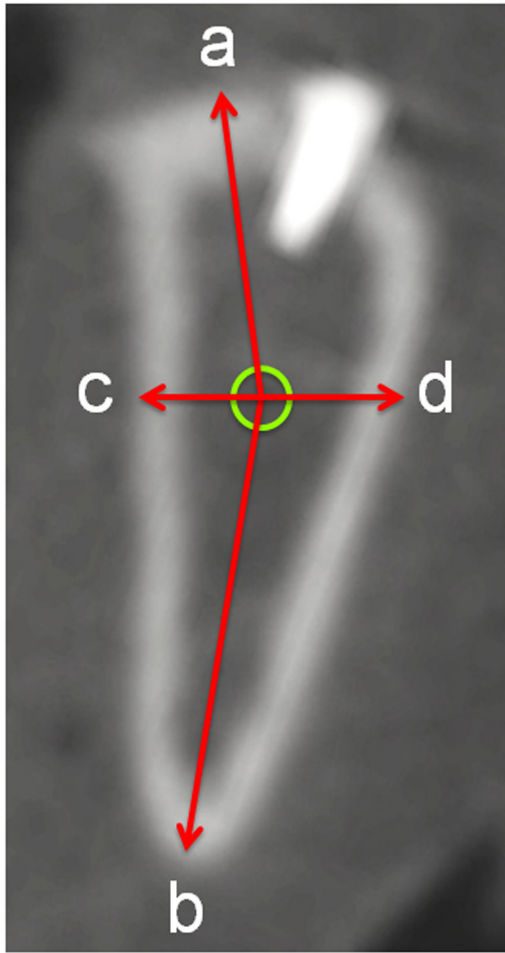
Example of a cross-sectional cone-beam computed tomographic (CT) view, showing the same region as Figure 1 (see the reference screw), and showing the corresponding measurements of the position of the mandibular canal (a, b, c, d).
